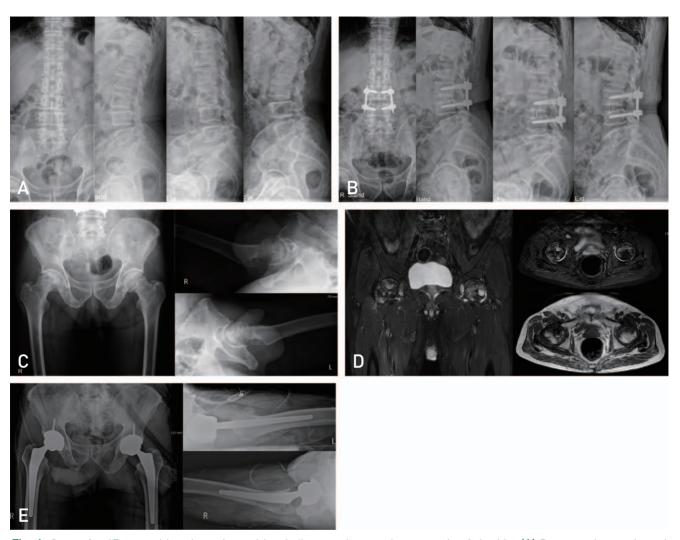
Case of a 67-year-old male patient with misdiagnosed avascular necrosis of the hip. (A) Preoperative static and dynamic radiograph image of the lumbar spine. (B) Preoperative static and dynamic radiograph image of the lumbar spine. (C) Preoperative anteroposterior, trans-lateral radiograph image of both hips. (D) Preoperative magnetic resonance image of both hips. (E) Postoperative anteroposterior, trans-lateral image of both hips.
